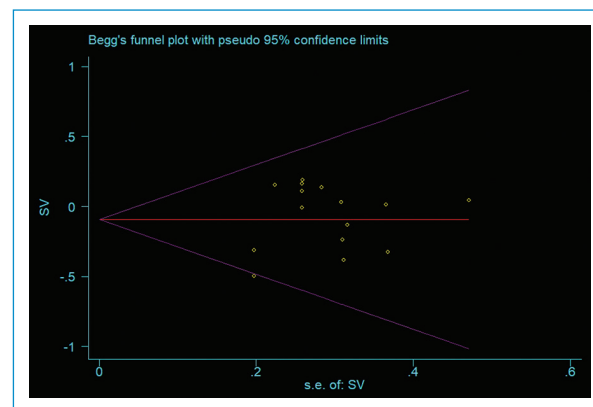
Funnel plot of publication bias for EF (MRA vs. CTA), Begg's p 0.553.
